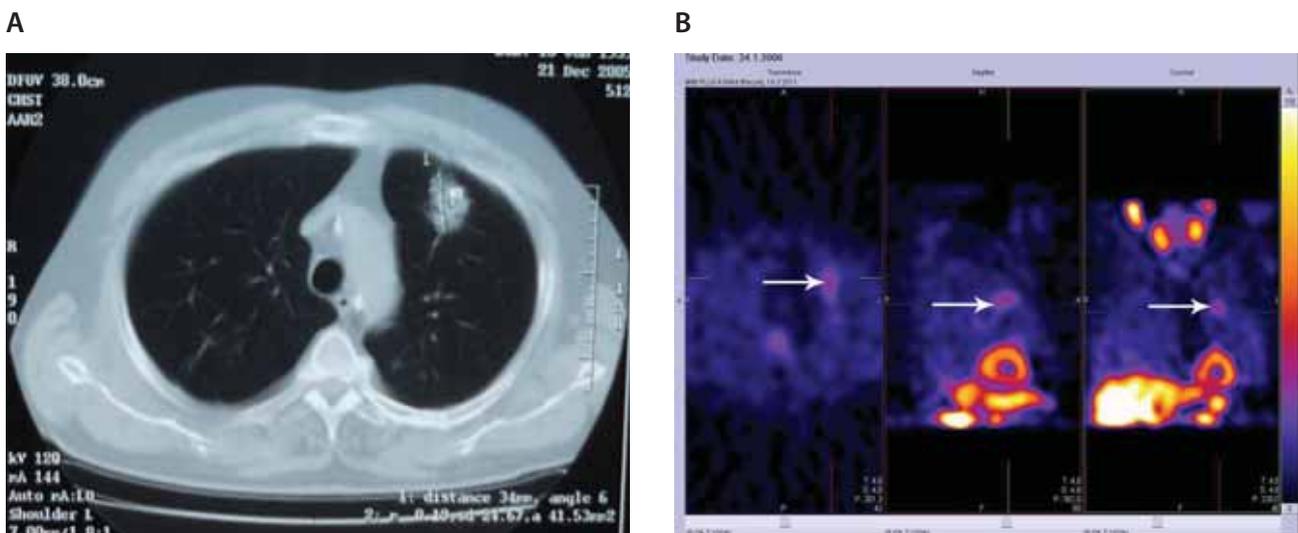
(A) CT scan of the chest of 67 year-old male patient revealing a 3.4 cm nodule in the left upper lobe (anterior segment) of the lung. (B) ^{99m}Tc -MIBI SPECT scan in the same patient showing moderately increased accumulation of ^{99m}Tc -MIBI in the lung region corresponding to the localisation of the nodule. At surgery the nodule was found to be medium differentiated squamocellular carcinoma.
